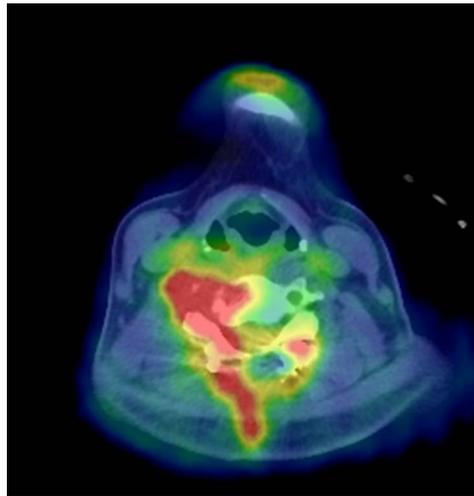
An axial fused positron-emission tomography/computed tomography (PET/CT) image shows an increase in the ^{18}F -FDG uptake in an osteolytic lesion at the right side of the C5 vertebral body and its paravertebral region.
